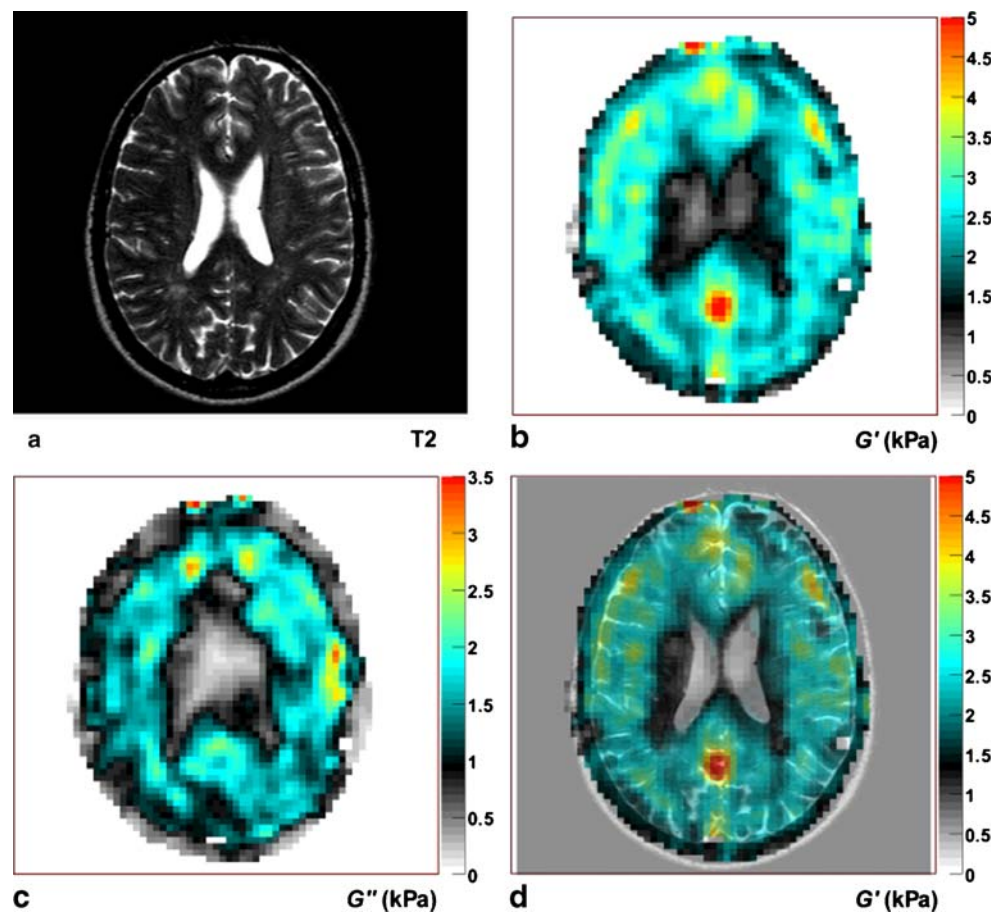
MR elastography of the brain. a T2-weighted brain image for anatomical reference; b shear stiffness map, after the application of shear waves propagating in the brain; c fusion of images. The shear stiffness
